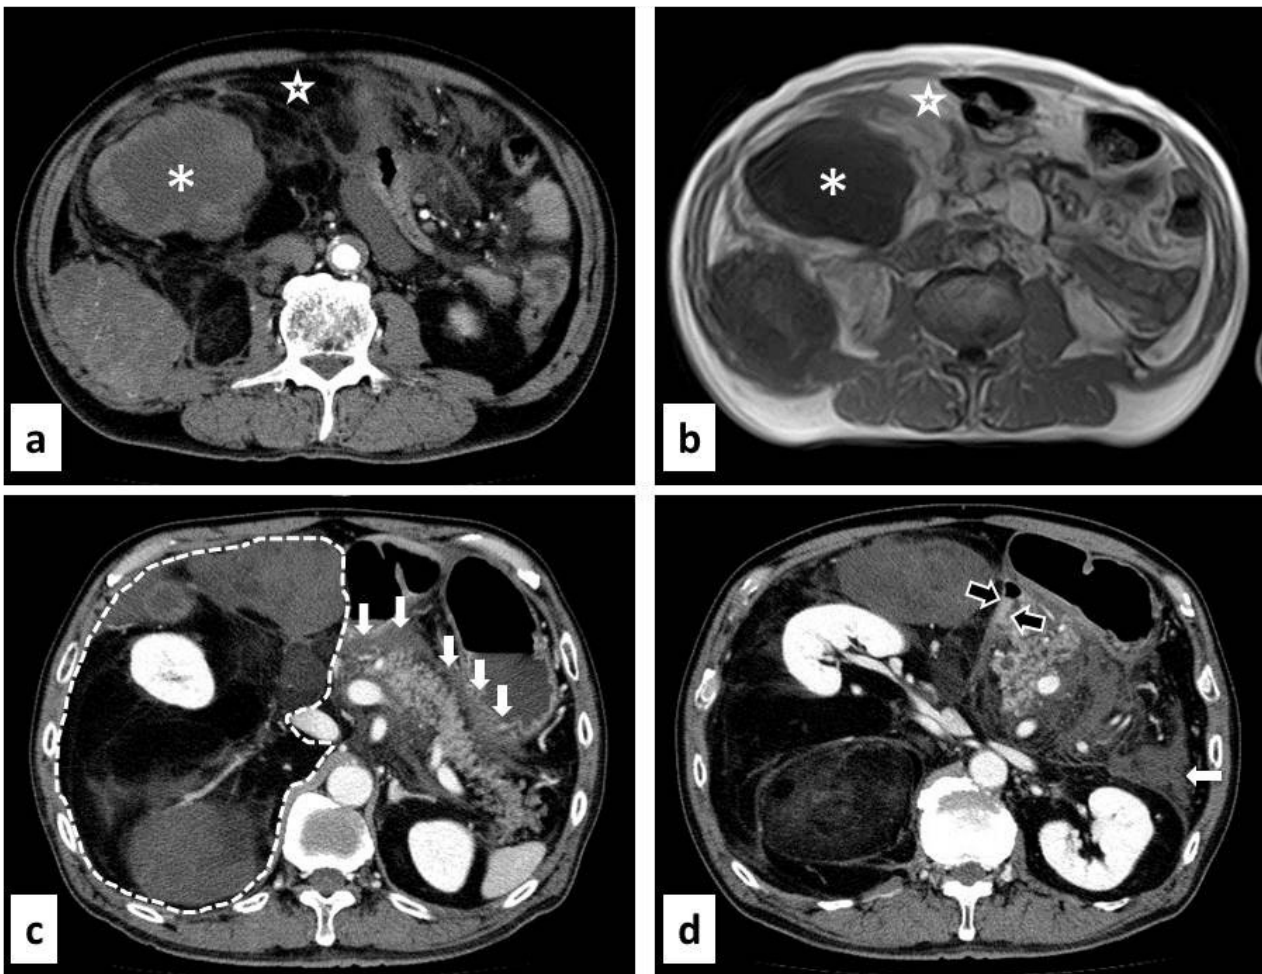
Finding of imaging modalities. a Enhanced computed tomography (CT) showed radiolucent fatty component (star) and several dense solid components enhanced with intravenous contrast containing central no enhancing part (asterisk). b Axial T1-weighted magnetic resonance image demonstrated fatty component (star) with high intensity signal and several solid components which contained dedifferentiated part (asterisk). c Enhanced CT showed a huge tumor lesion, occupying right abdominal space (dotted line), the irregular pancreatic outline, obliterated peripancreatic fatty tissue (arrow). d Enhanced CT showed the duodenum was compressed by tumor (unfilled arrow) and the fluid in the left anterior pararenal space (arrow).
